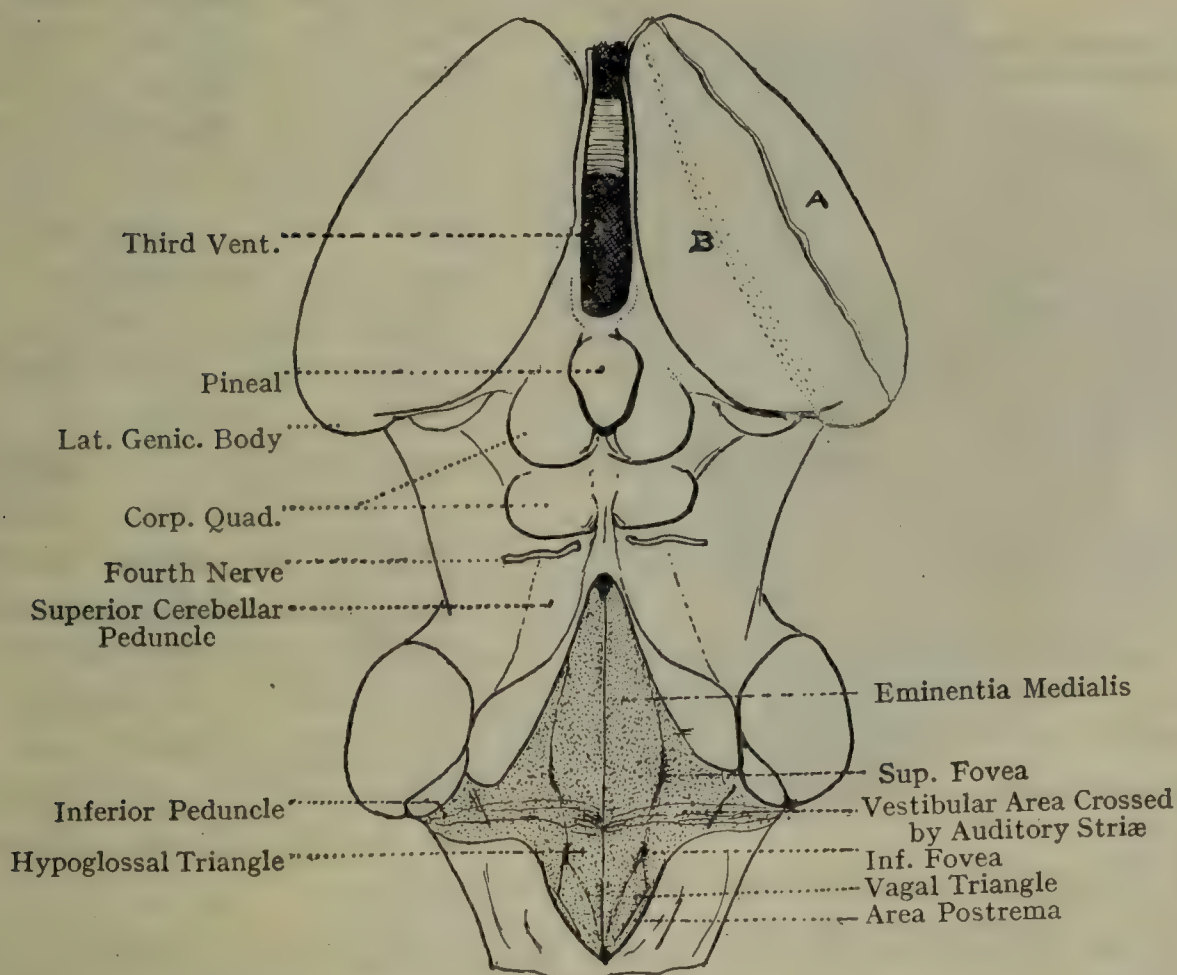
POSTERIOR ASPECT OF MID- AND HIND-BRAINS.
